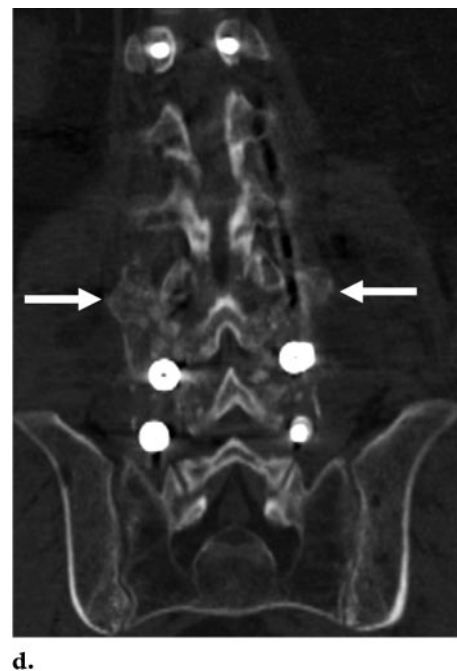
Utility of multidetector CT in evaluation of non-union. (a) Anteroposterior radiograph demonstrates multilevel pedicle screw and rod instrumentation with a corpectomy at L3 and reconstruction with a humeral strut graft and lateral side-plate and screws. Areas of lucency around the inferior pedicle screws are indicative of loosening (arrowheads). (b) Coronal CT image clearly shows areas of lucency around the inferior pedicle screws (arrows). (c) Coronal CT image in a more posterior plane than b demonstrates the dense, granular appearance of the graft material (arrows), a finding indicative of a lack of graft incorporation into a solid fusion construct at this inferior level. (d) Coronal CT image in a more posterior plane than b and c shows adequate formation of a posterolateral osseous fusion complex at higher levels (arrows).
